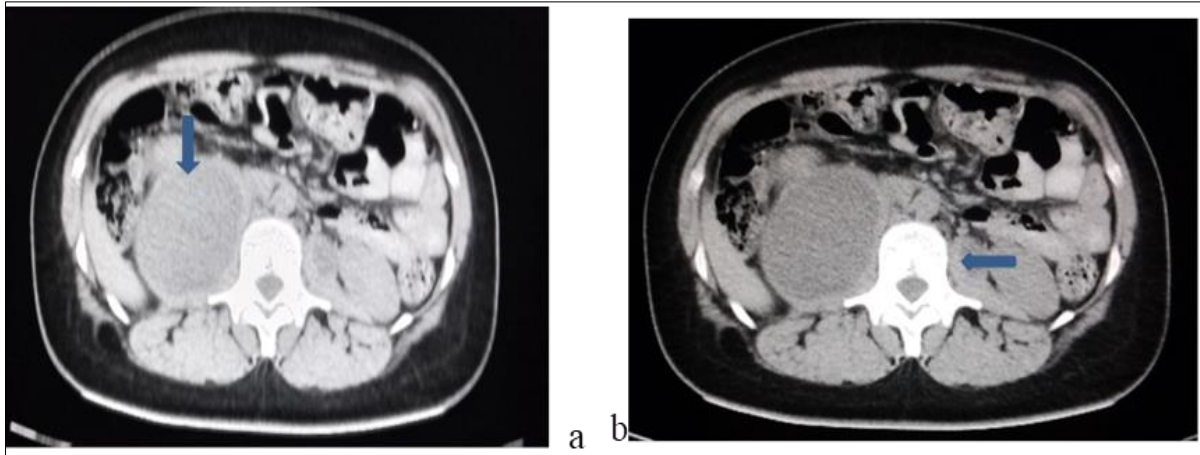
and 2b are axial non-contrast enhanced and contrast enhanced CT scan images of the abdomen showing the both psoas muscles with collections seen within. It showed rim enhancement with administration of contrast.(slimmed body blue arrow for right psoas muscle and yellow slimmed body arrow for left psoas muscle respectively)
